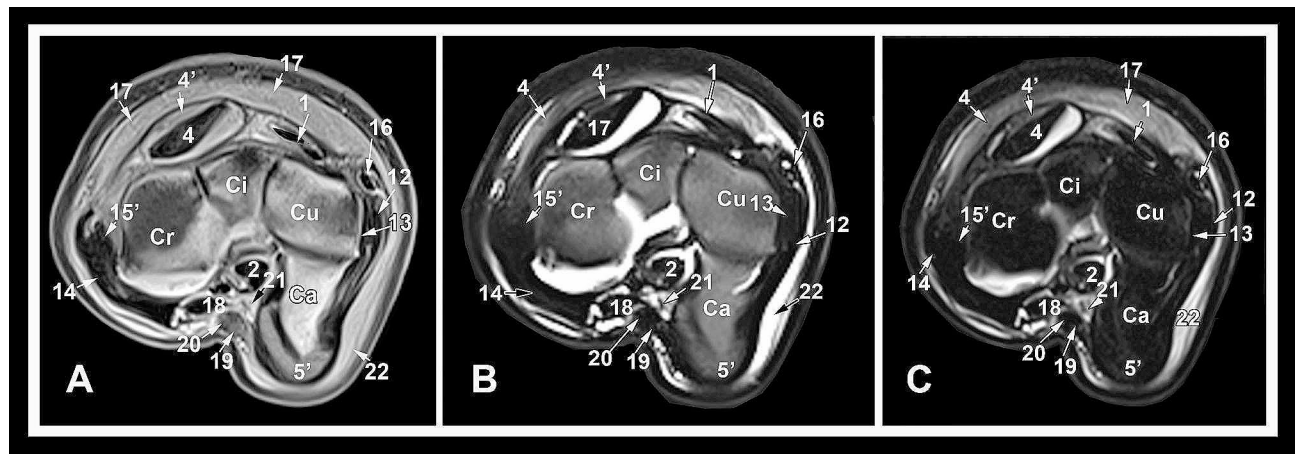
Transverse T1 (A) and T2-weighted (B) and STIR (C) high-field MRI images at the level of the proximal row of carpal bones. Cu, ulnar carpal bone; Ci, intermediate carpal bone; Cr, radial carpal bone; Ca, accessory carpal bone; 1, common digital extensor tendon; 2, deep digital flexor tendon; 4, radial carpal extensor tendon; 4', radial carpal extensor tendon sheath; 5', origin of the superficial digital flexor tendon; 12, long lateral collateral carpal ligament; 13, proximal part of the short lateral collateral carpal ligament; 14, long medial collateral carpal ligament; 15', short medial collateral carpal ligament; 16, lateral digital extensor tendon; 17, extensor retinaculum; 18, radial carpal flexor tendon; 19, median artery; 20, median vein; 21, median nerve; 22, flexor retinaculum
